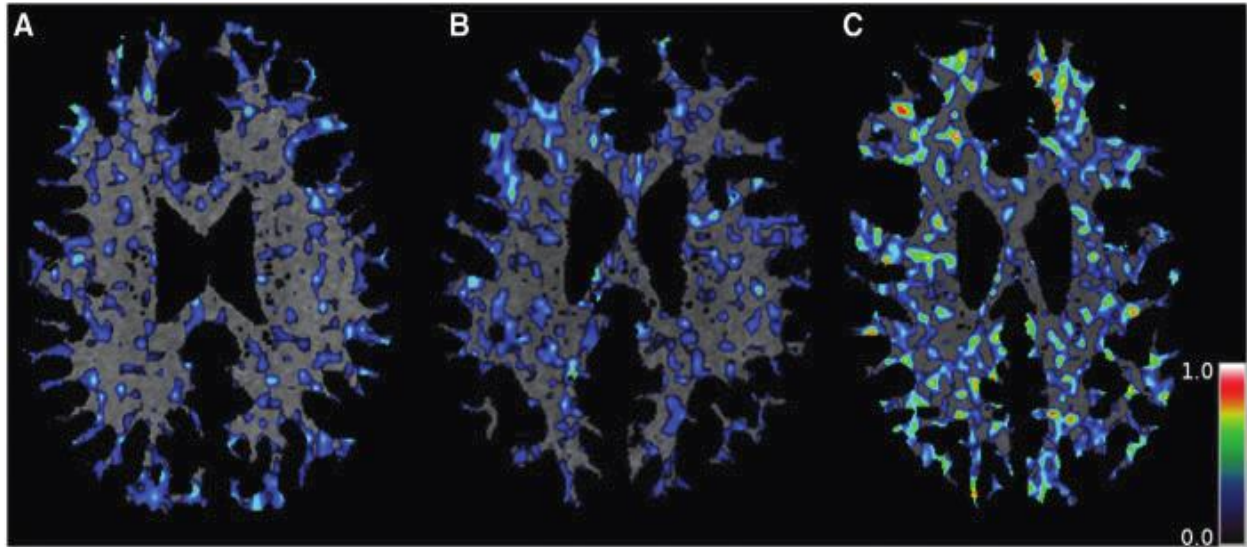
Normal appearing white matter on PK11195-PET images co-registered with MRI in three study subjects. The first subject is a healthy control (A) with PK11195 binding potential (BPND) in NAWM of 0.028; the second is a CIS subject without T₂ MRI lesions (B), an EDSS score of 3.5 and PK11195 BPND in NAWM of 0.037; the third is a CIS subject with T₂ MRI lesions (C), EDSS = 2.0 and PK11195 BPND in NAWM of 0.136. The color scale bar represents the BPND of PK11195. From Giannetti et al., *Brain*, 2015 [78].
